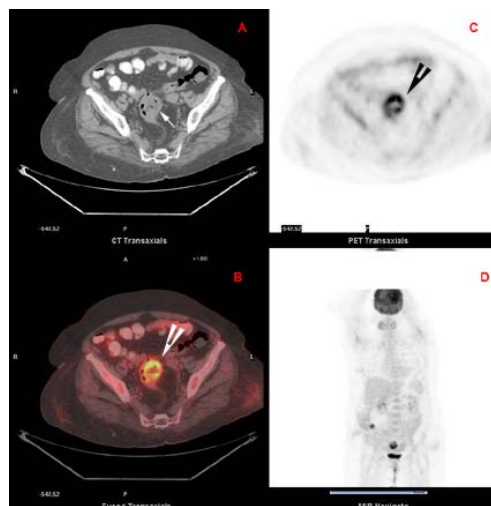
Transaxial images from ^{18}F -FDG-PET/CT study, CT (A), fused PET/CT (B), PET only (C) and MIP (D) showing uptake in the sigmoid colon (arrow head). Computerized tomography image (A) shows focal wall thickening, pericolic fat infiltration and peritoneal thickening in the distal sigmoid colon (arrow). A small air-containing cavity lined by thin epithelium is noted in the serosal surface, which is consistent with the pseudodiverticulum.
